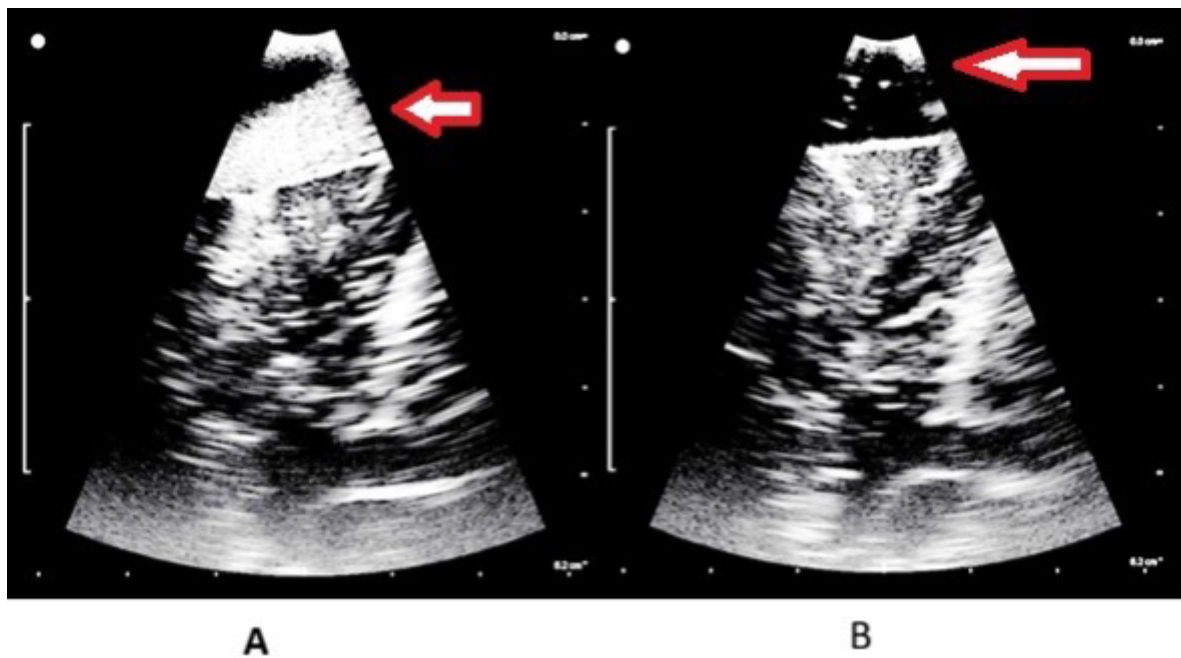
An example of intraoperative ultrasound: A) Pre-drainage demonstrating a double layer of hematoma; B) Post-drainage demonstrating a starry sky appearance signifying complete clearance, no membranes seen; Red closed arrows point towards hematoma.
